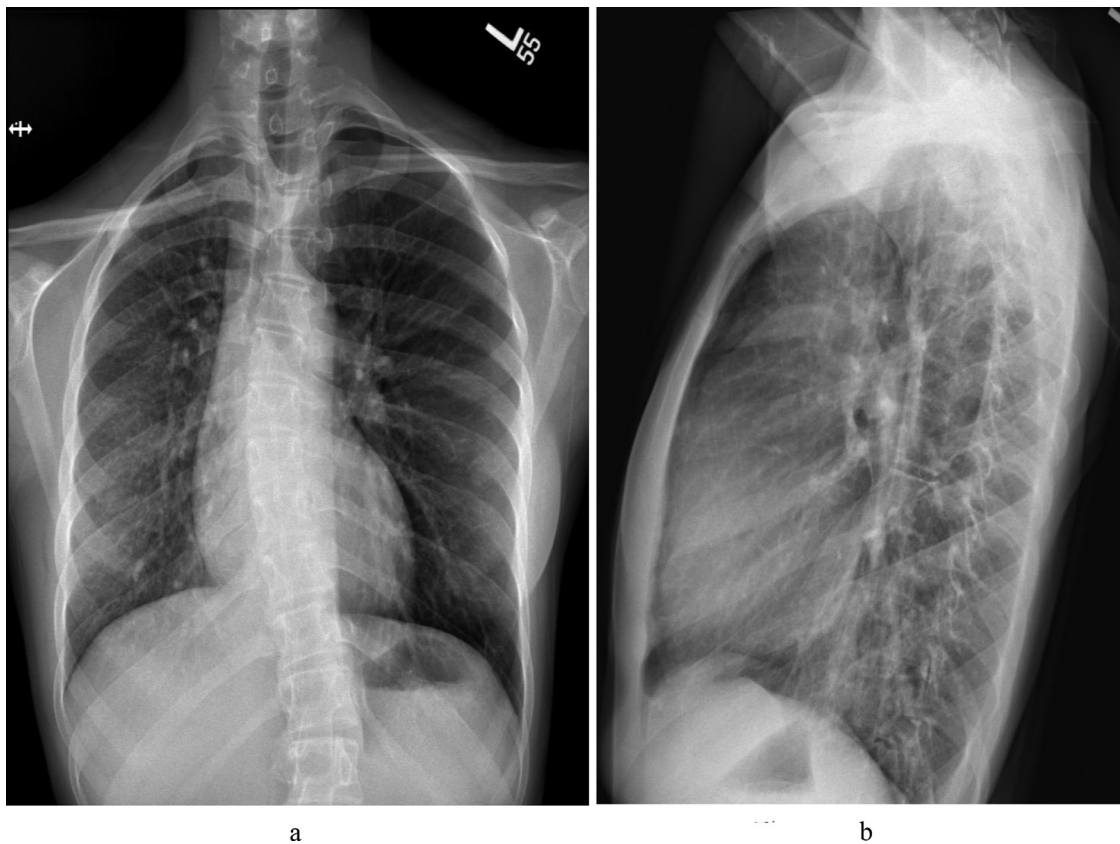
Frontal (a) and lateral (b) chest radiographs show mild volume loss of the right lung with mild rightward mediastinal shift. Heart size is normal. There are ground-glass opacities of the right lung and mild interstitial thickening. No pleural effusion. Spinal scoliosis is seen, which is of no clinical significance to our case.
